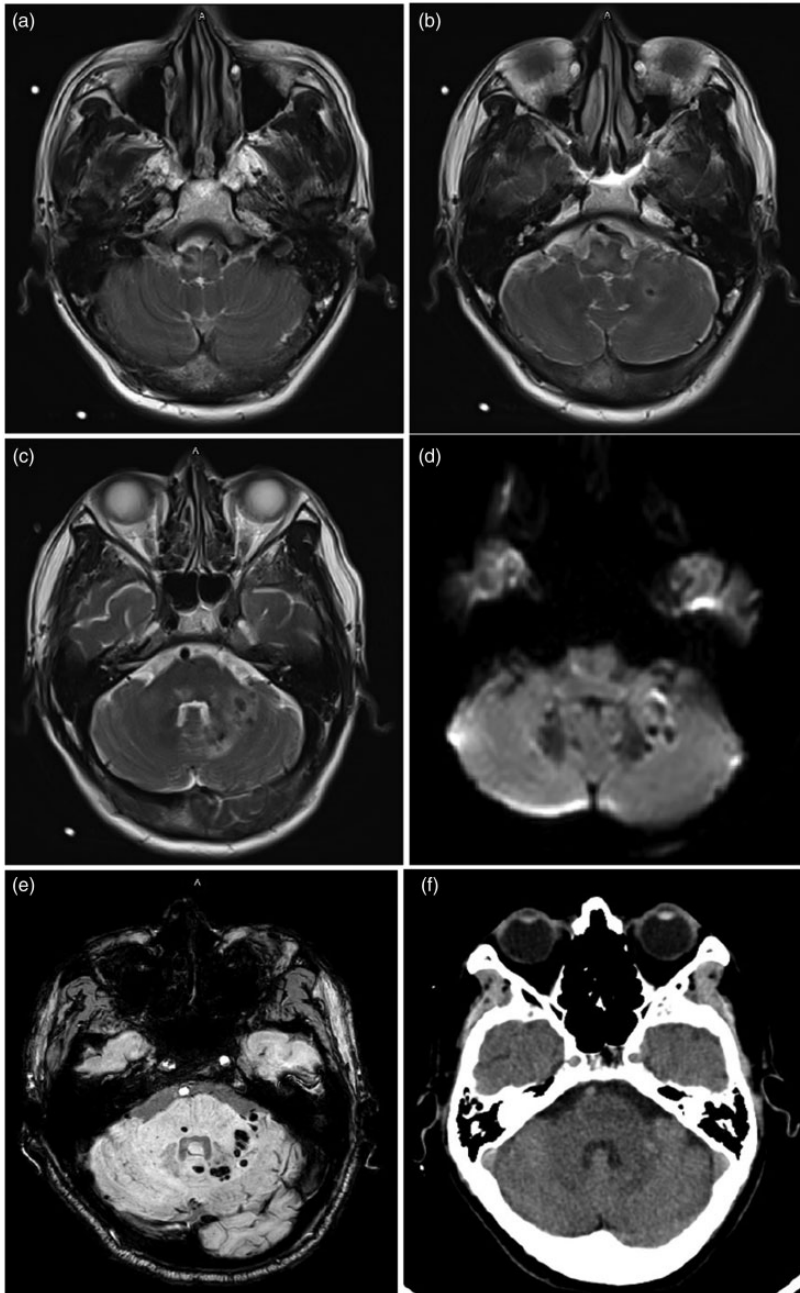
Brain imaging of a patient with *Listeria monocytogenes* rhombencephalitis. Different levels of T2-weighted imaging (T2WI), diffusion-weighted imaging, and susceptibility-weighted imaging in brain magnetic resonance imaging are shown (a–e). Multiple high signals mixed with low signals in the pons, medulla oblongata, and left cerebellar hemisphere appeared in T2WI (a–c) and diffusion-weighted imaging (d). Low signals in susceptibility-weighted imaging suggested that the lesions were a hemorrhagic manifestation (e). Brain CT imaging shows several speckle-like hypersignals (f). Similar levels of T2WI in brain magnetic resonance imaging as shown in panels a–c show that intracranial lesions are slightly reduced after treatment (g–i).
